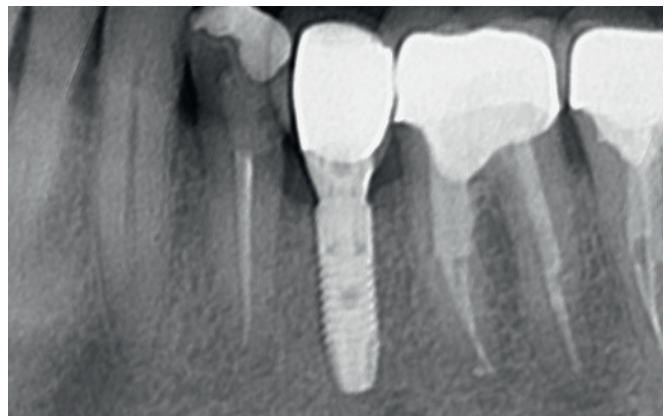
Follow-up x-ray at 6 years.
